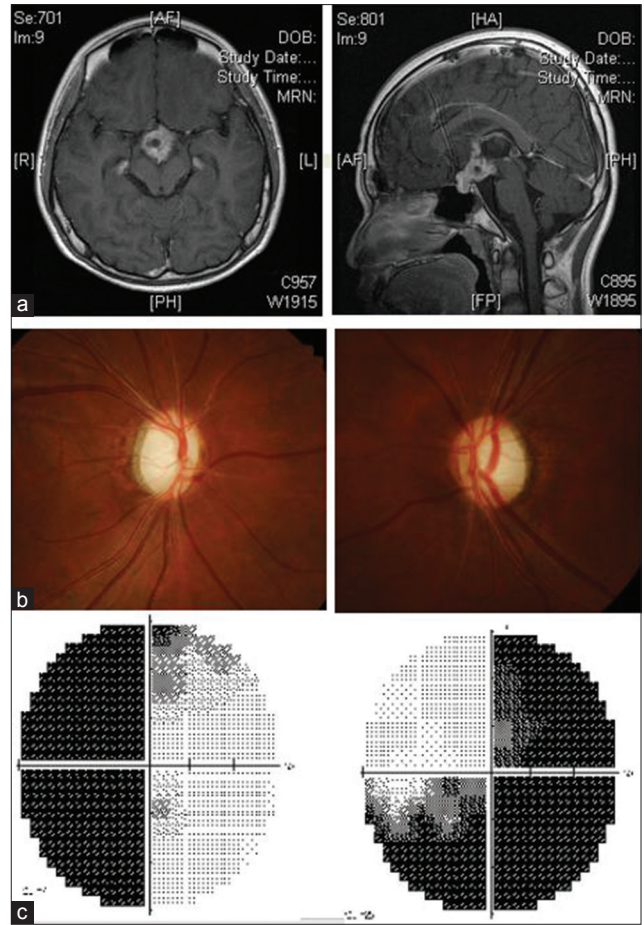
(a) Head magnetic resonance imaging before operation showed a sellar mass with suprasellar extension. (b) Both discs are pale. (c) Visual-field examination showed bitemporal hemianopia along with inferonasal defect in the right eye
